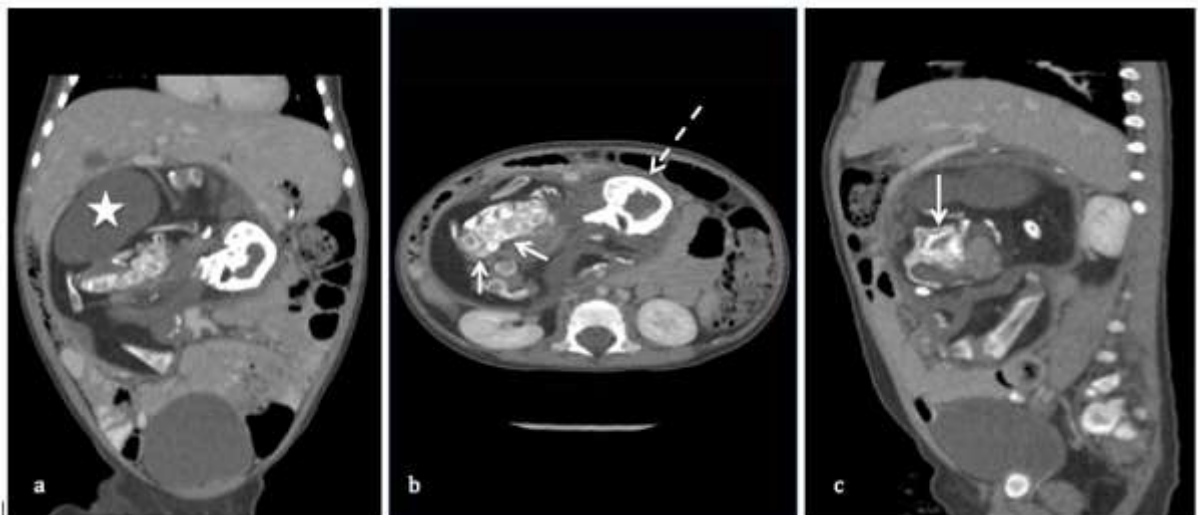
a) Coronal, b) axial and c) sagittal CT abdomen images show a complex mass with variable soft tissue density within its own cavity. Bony component resembling skull (white dotted arrow) and cystic lesion arising from adjacent vertebra-like structure (white arrows); which is presumed to represent a myelomeningocele (white star), but turns out to be granulomatous inflammation.
